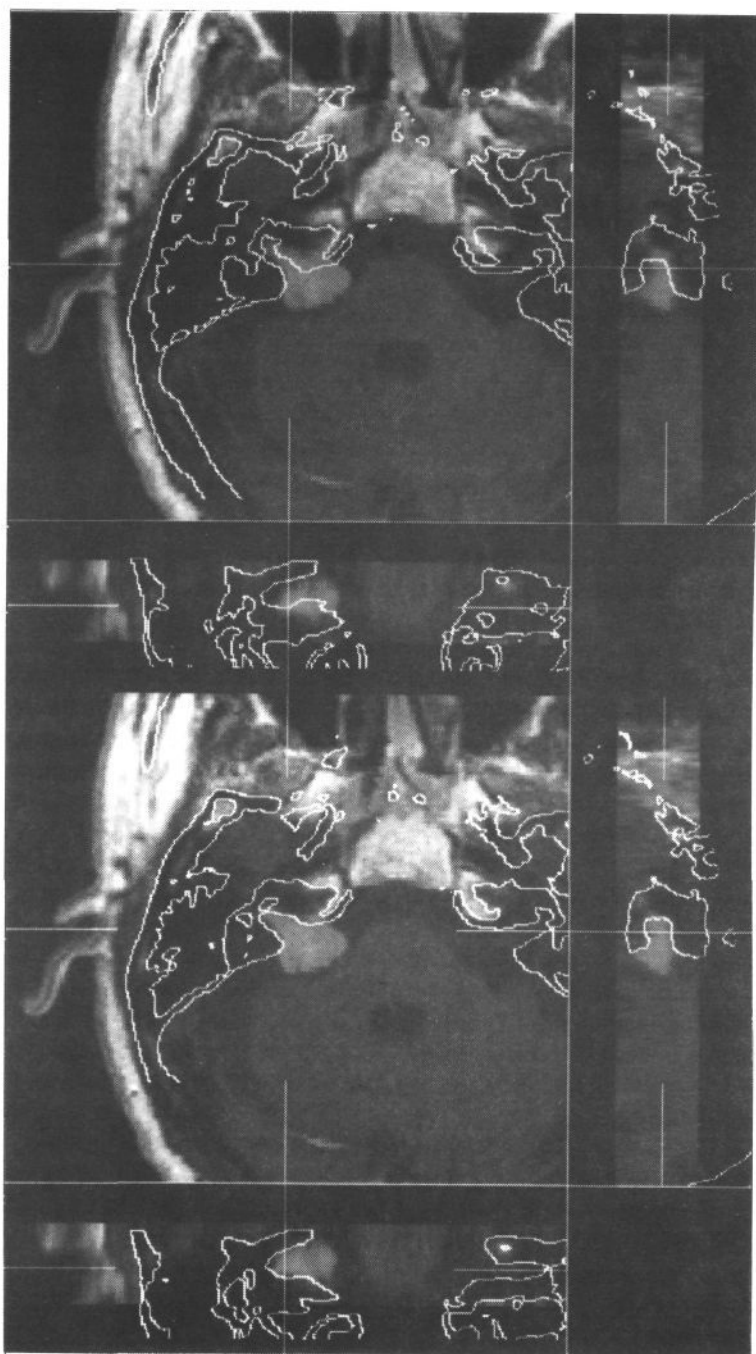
Orthogonal slices through a point inside the internal auditory canal in the MR grey level image for patient E. Registration results for relative entropy using full volume (top) and intra-cranially truncated (bottom) CT are shown by overlay of CT bone threshold boundary in white.
